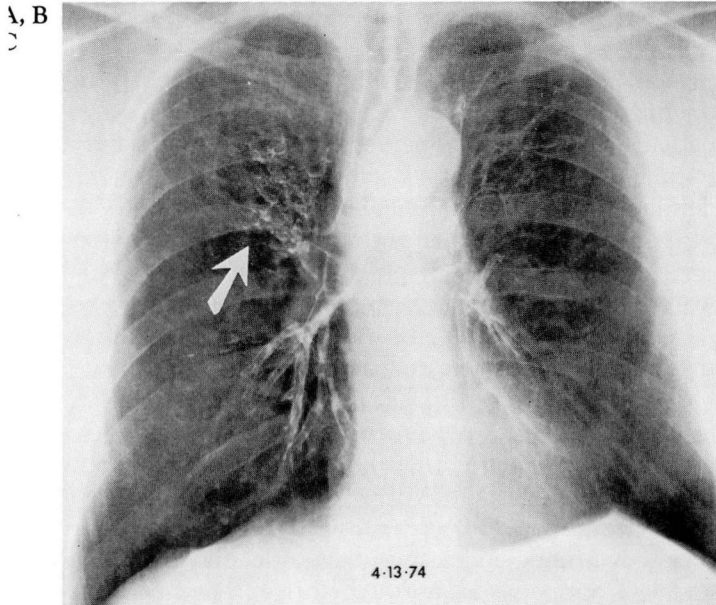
Bronchogram demonstrating changes of proximal saccular bronchiectasis in the right upper lobe (arrow). FIGURE 3B. Chest radiograph of the same patient six years later during an exacerbation of his ABPA revealing left middle and lower lung field infiltrates. FIGURE 3C. Radiograph six months later demonstrating clearing of the left lung infiltrates.
